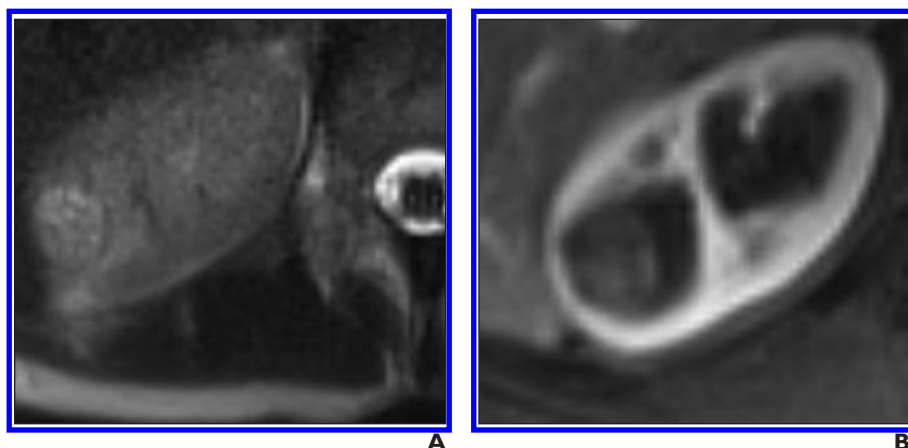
56-year-old woman with pathologically proved chromophobe renal cell carcinoma. A and B, Axial HASTE (A) and axial corticomedullary phase 3D gradient-echo T1-weighted (B) MR images show well-circumscribed mass of heterogeneous T2 signal intensity and enhancement that is predominantly hyperintense to renal cortex in A and hypointense in B. No central scar or segmental enhancement inversion was detected.
